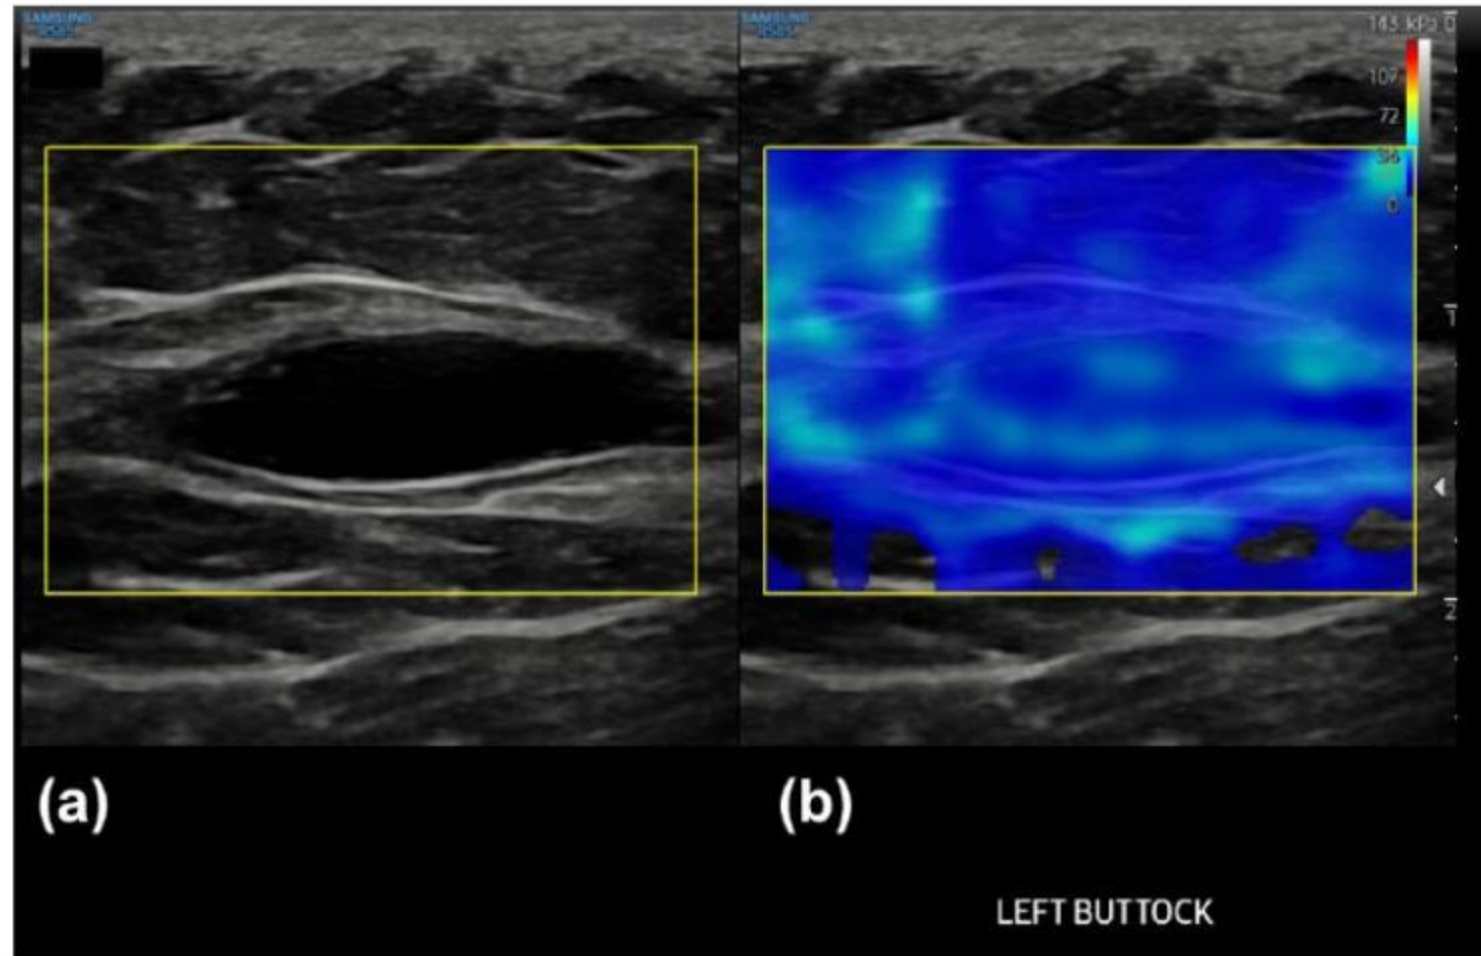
(a) Transverse ultrasound image of a haematoma in the subcutaneous tissues of the left buttock. (a) The B-mode image. (b) The lesion has the same stiffness as the surrounding subcutaneous tissues. The haematoma was followed up and had resolved on a subsequent ultrasound scan.
